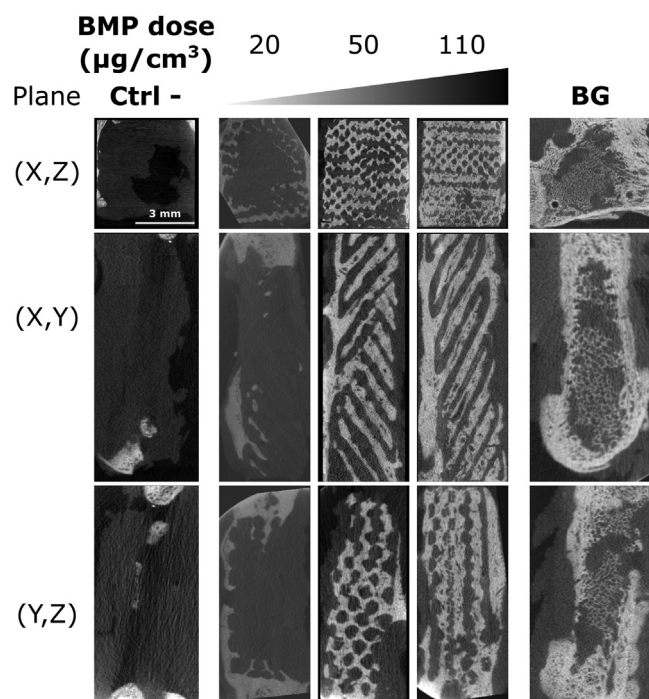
Representative μ CT images in the three sectional planes (see Fig. 1) for the film-coated scaffolds containing increasing doses of BMP-2 from 20 to 110 $\mu\text{g}/\text{cm}^3$. The negative control (Ctrl -, film-coated scaffold without BMP-2) is shown on the left, whereas the BG is shown on the right-hand side.
